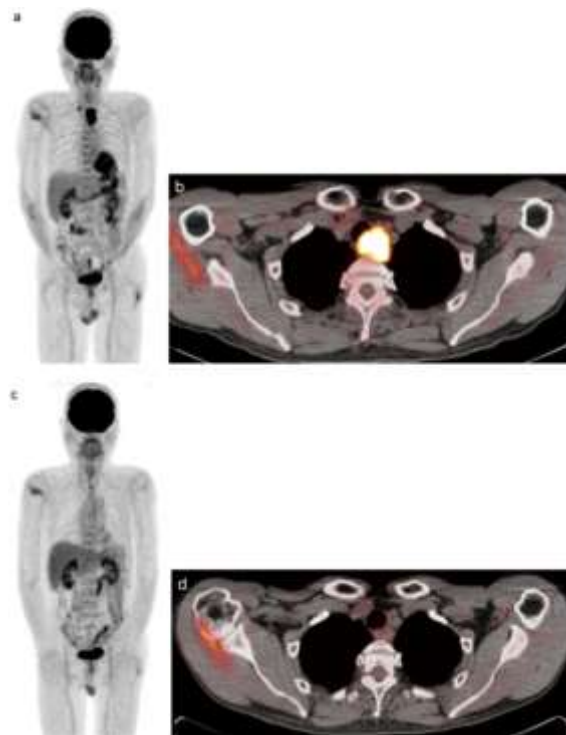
FDG-PET/CT scan of an advanced esophageal cancer, (a) Pretreatment PET scan shows two areas of strong FDG uptake (b) Pretreatment FDG-PET/CT scan shows a maximum standardized uptake value (SUVmax) in the primary tumor, (c) Three months post treatment PET scan showing faint FDG uptake and (d) FDG-PET/CT scan [71].
